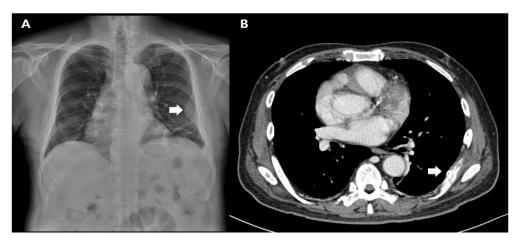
(A) Chest x-ray shows a mass-like lesion on the left pleura (arrow). (B) Chest CT scan shows the destruction of the left 8thrib (arrow).
